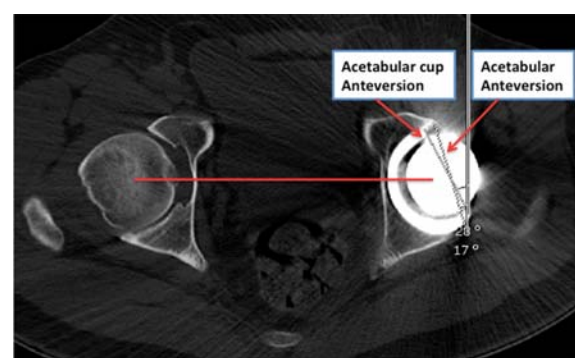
Measurement of the difference in anteversion between the bony acetabulum and the acetabular cup from a CT scan of both hips.
